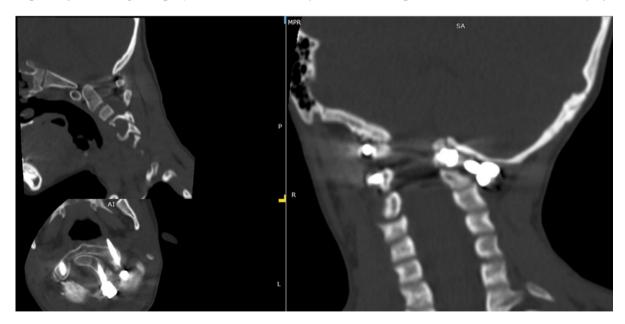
CVJ MRI image(a-lateral, b-axial, c-frontal reconstruction) demonstrates a pronounced left-sided LAAD and a 90-degree instrumentation malposition. No resorption area can be seen around the screws, meaning they preserve their fixed position despite the dislocation
